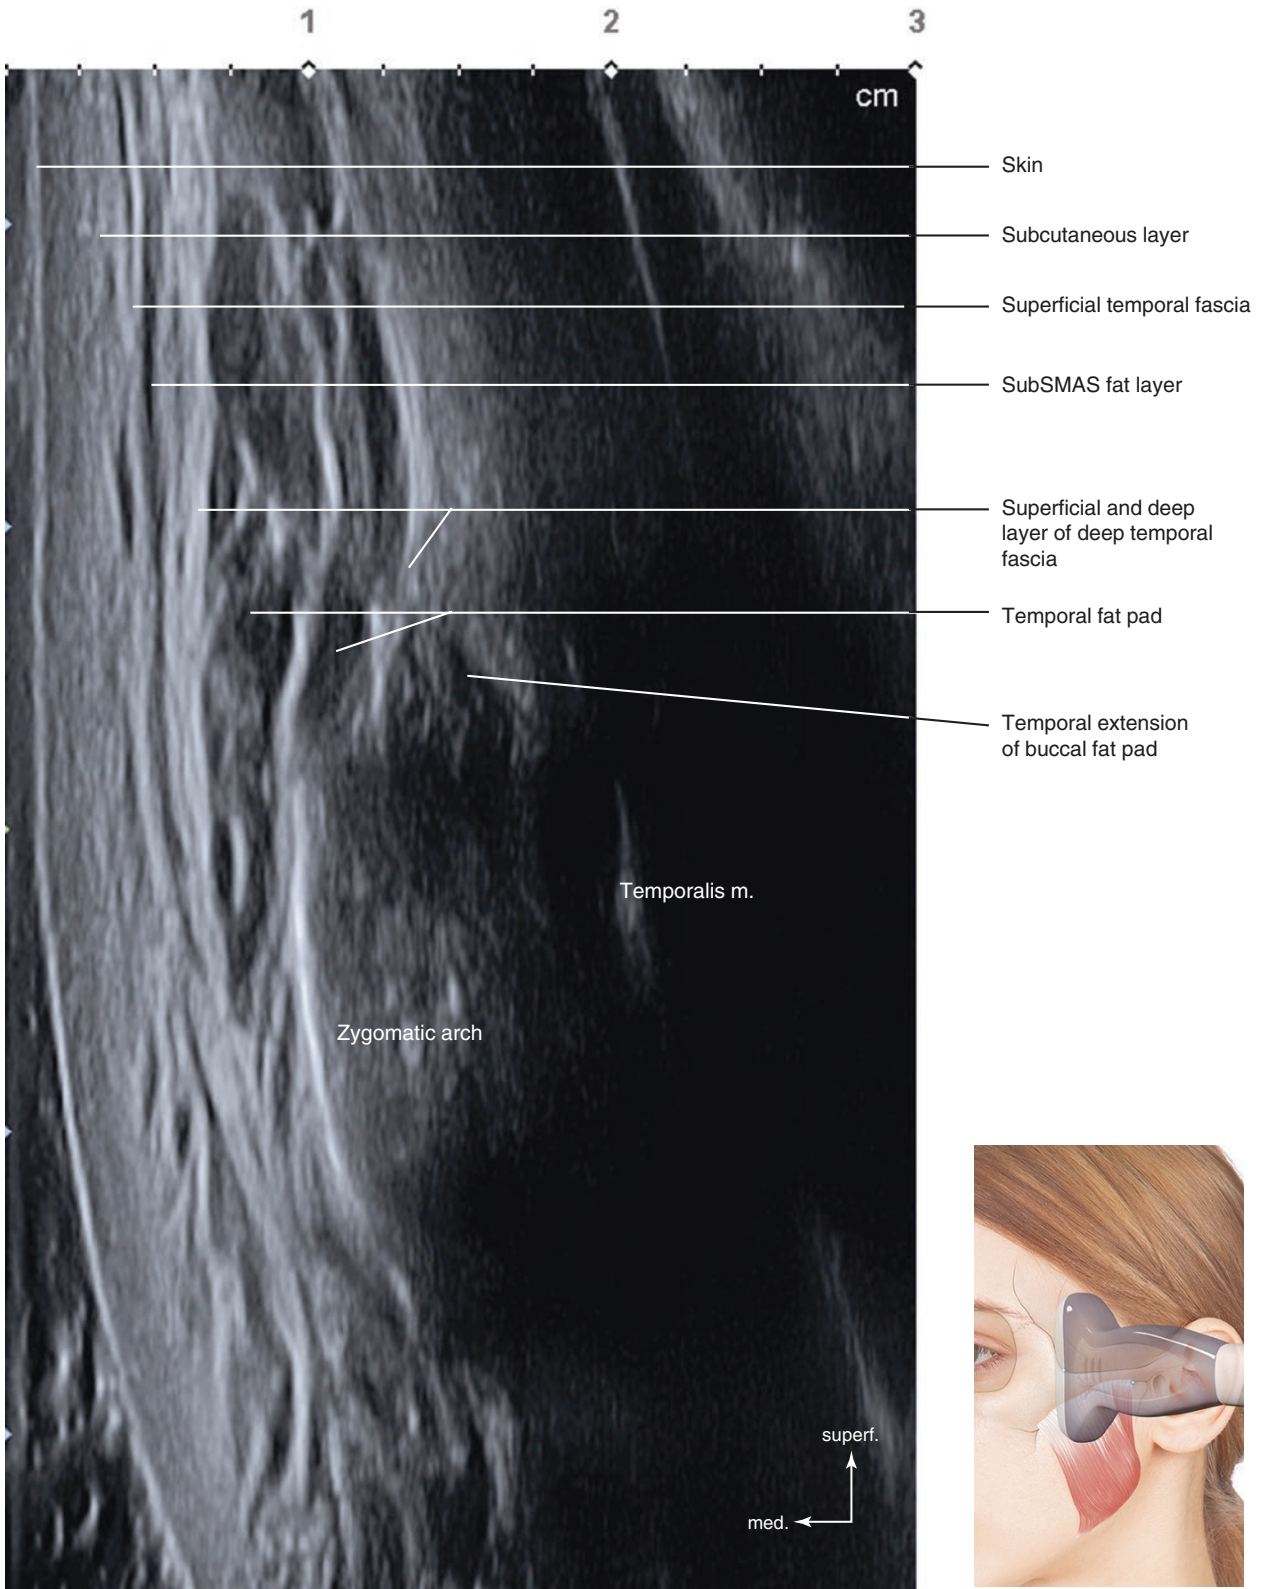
Ultrasonography of the perpendicular line passing the jugale (T3). B mode (coronal view, 15 MHz by linear transducer). (Published with kind permission of © Hee-Jin Kim 2020. All Rights Reserved)
